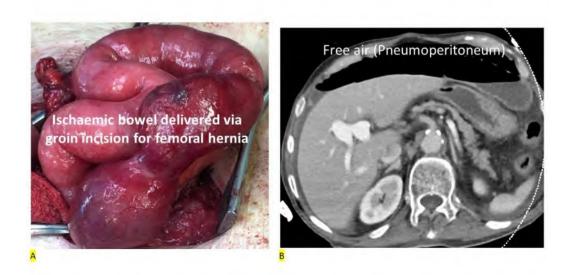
Visualizing the intrabdominal space for free air through computed tomography.
